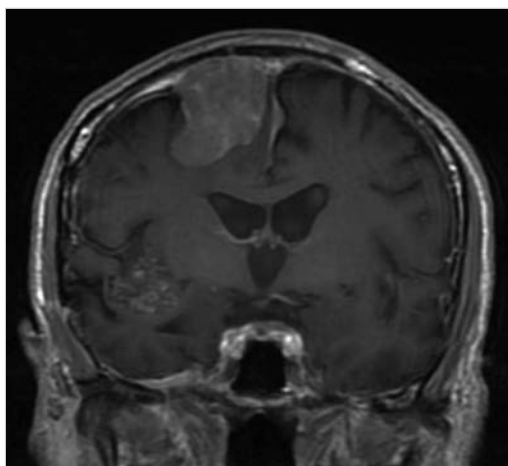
Coronal postcontrast T1-weighted MRI depicting a medially located meningioma.
